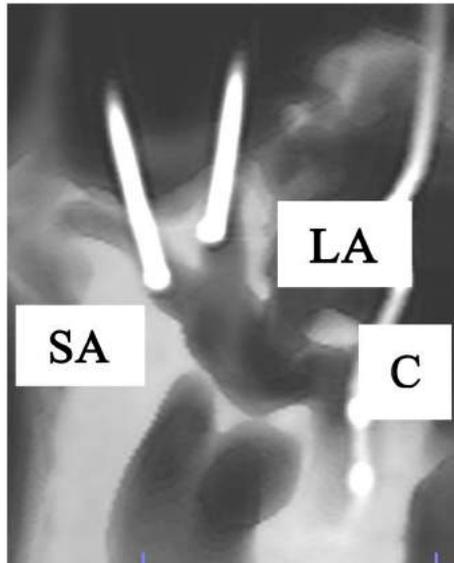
Anterolateral view of a right temporal bone using cone beam CT-scan. It shows the fenestration and insertion of the cochleovestibular electrodes in the superior ampulla (SA), lateral ampulla (LA), and cochlea(C).
